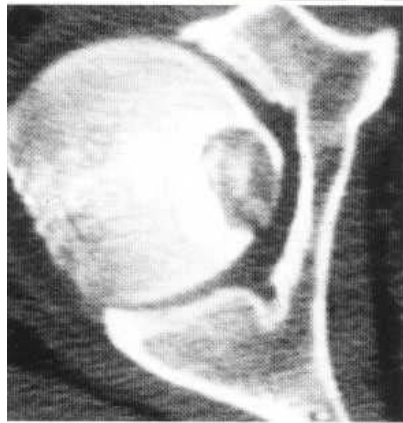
Chondroblastoma of the femoral head. The CT image demonstrates a destructive subchondral lesion containing areas of calcification within it and bordered by a sclerotic rim.
